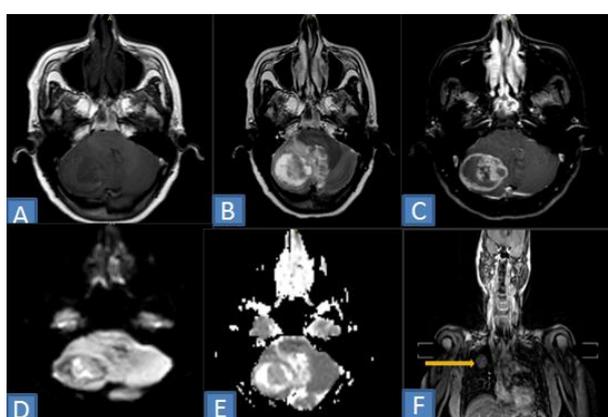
A case of cerebellar metastasis proved to be due to Ca Bronchus appearing hypointense on T1WI (A), heterogeneously hyperintense on T2WI (B), showing peripheral and heterogeneous enhancement in contrast study (C), showing restriction diffusion on DWI (D) with low ADC values (E). MRI chest (F) showing Ca Bronchus in right upper lobe (yellow arrow).
